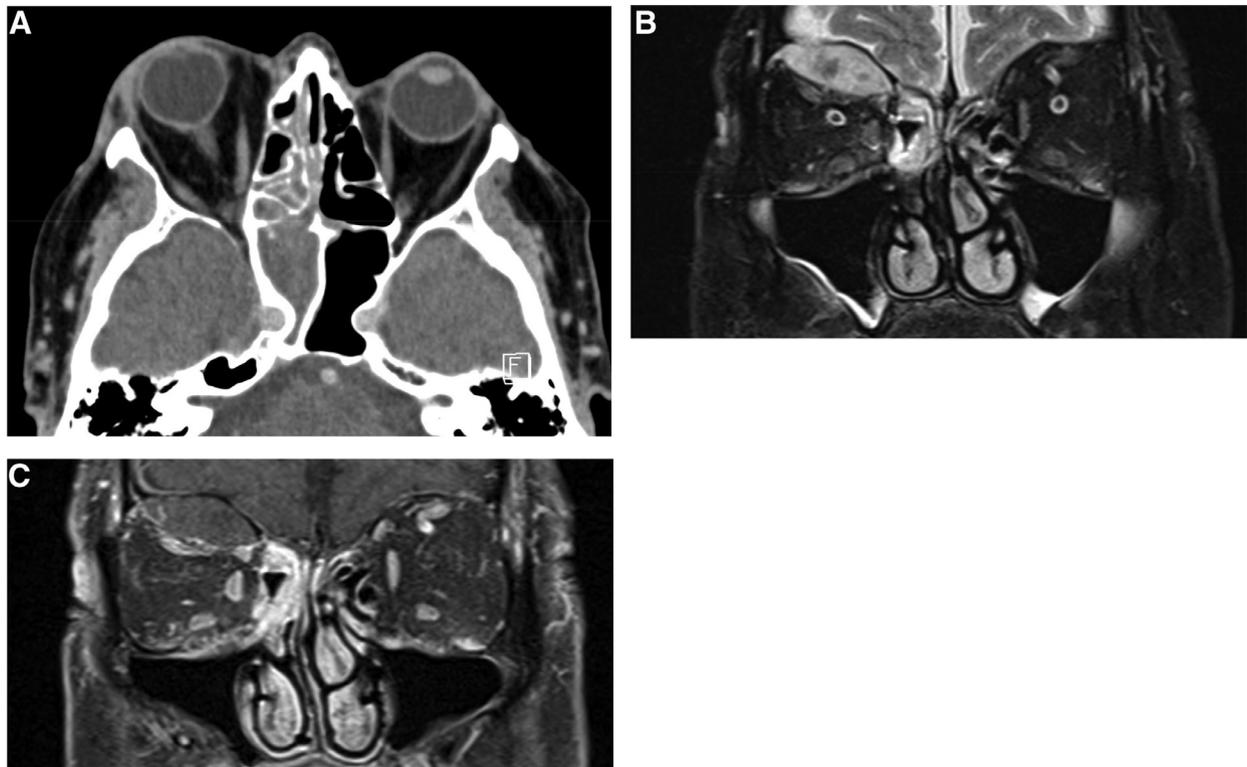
(A) Coronal computed tomography demonstrating opacification of the right sphenoid and ethmoid sinuses. (B) T2-weighted fat-suppressed coronal magnetic resonance imaging (MRI) showing a hyperintense superior orbital lesion with central areas of hypointensity. (C) T1-weighted fat-suppressed coronal MRI showing a nonenhancing superior orbital mass.
